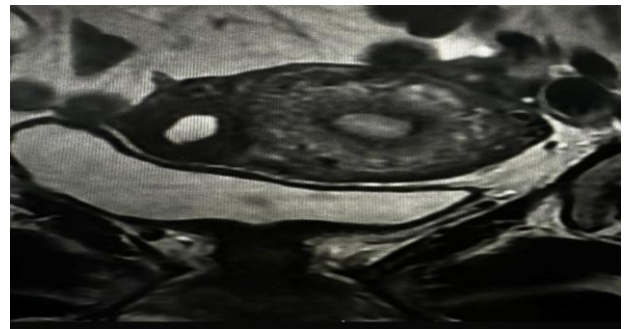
MRI pelvis demonstrating a cavitated lesion in the uterine wall consistent with accessory cavitated uterine mass (ACUM).
